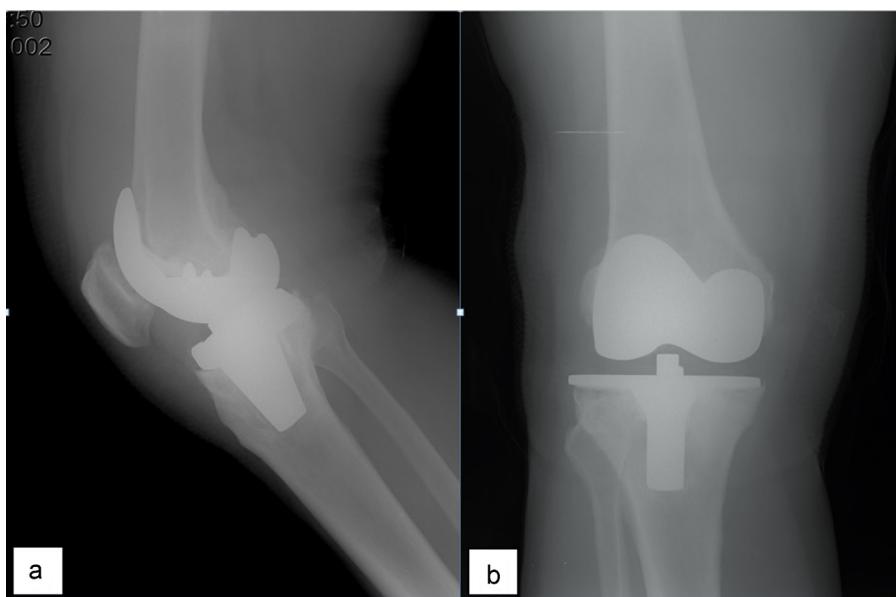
Pre-operative anteroposterior (a) and lateral (b) radiographs of the knee show loosening and osteolysis under the tibial component in the medial compartment.
